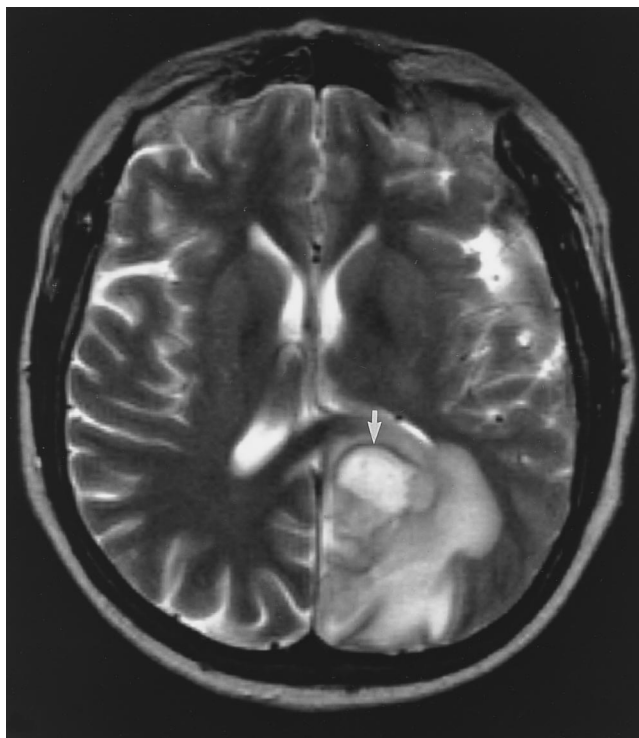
T2-weighted MRI scan of the brain of the patient in figure 1 shows a hyperintense abscess cavity surrounded by a hypointense capsule (arrow) and surrounding edema (hyperintense on scan).
